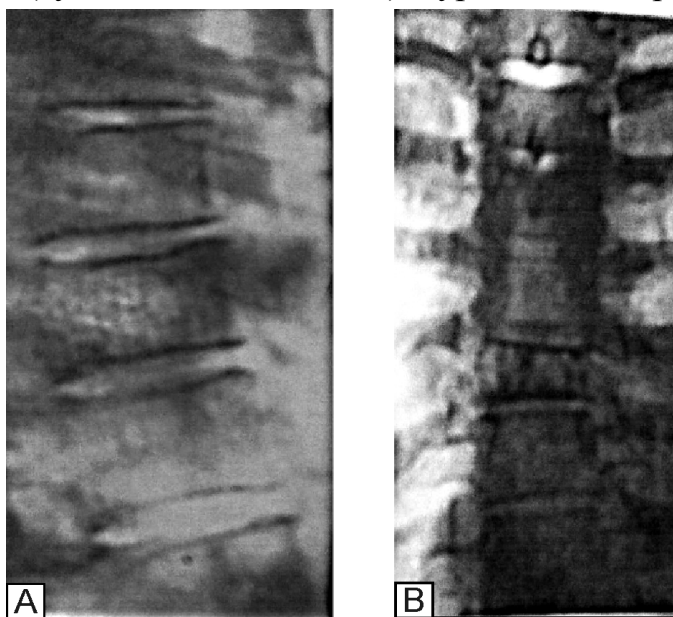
X-ray pictures of the thoracic spine of patient T. A — lateral projection; B — frontal projection. There is determined spongy structure of the body of Th XI with a decrease in its height in the anterior parts with manifestations of compression
